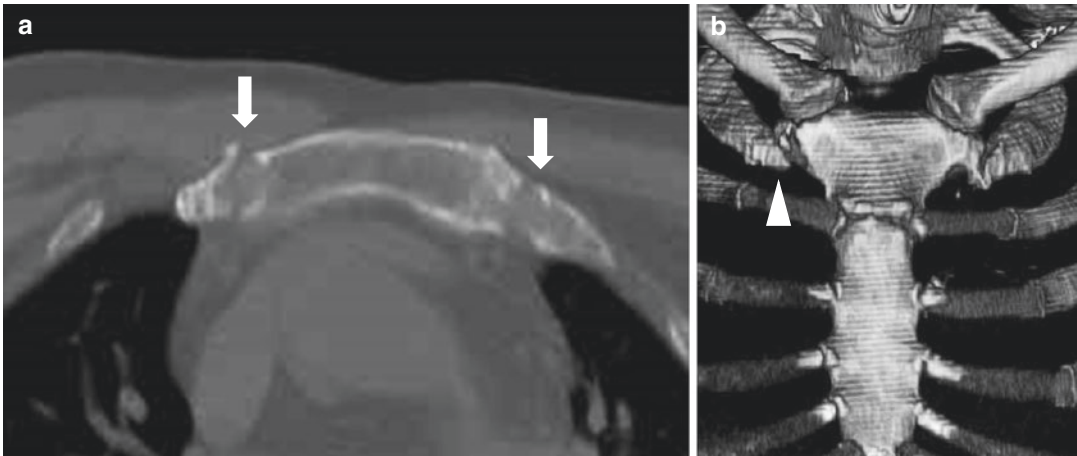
Axial CT image (a) and 3D reconstruction (b) of a fracture of the first sternochondral joint (arrows in a) with right dislocation (white arrowheads in b)
